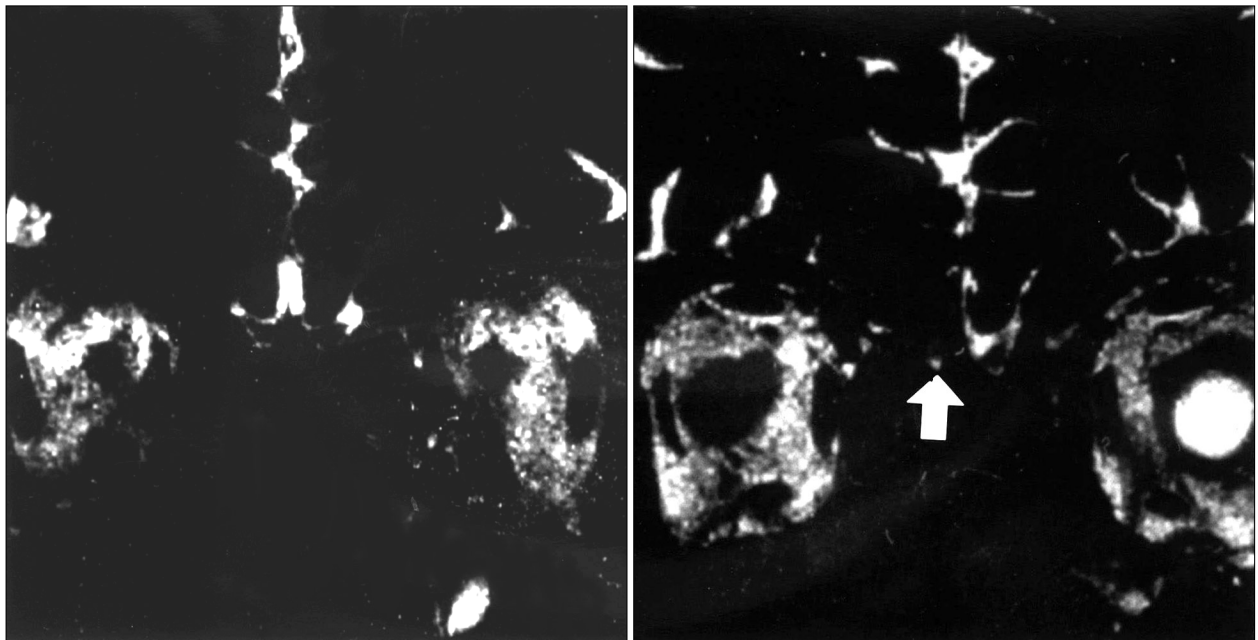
Magnetic resonance imaging of another one anosmic patient showing absence of right olfactory bulb (arrow) and narrow cisternal space around the olfactory bulbs.
